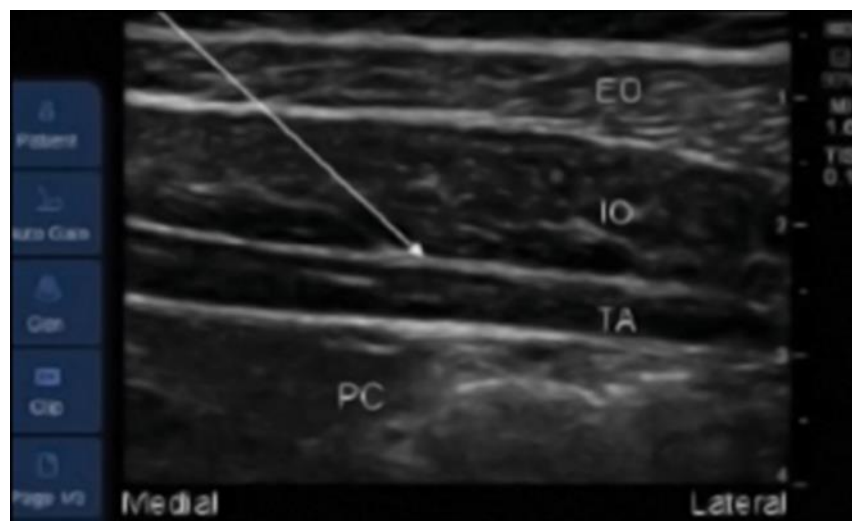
Ultrasound guided image of TAP block (36).
